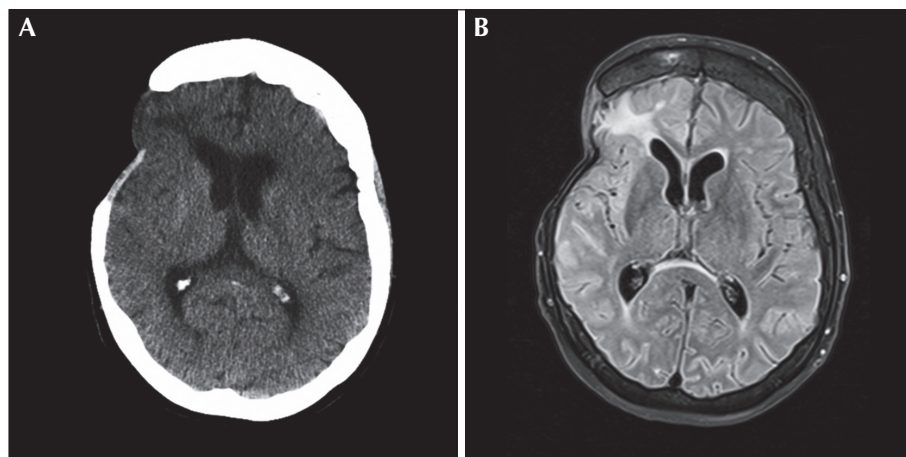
(A) Head CT without contrast demonstrating post-operative changes with skull defect and encephalomalacia in the right temporal and frontal lobes. (B) MRI T2 fluid attenuation inverse recovery (FLAIR) demonstrating known encephalomalacia and mild increased signal of the right insular cortex and posterior frontal operculum, felt to represent post-ictal changes.
